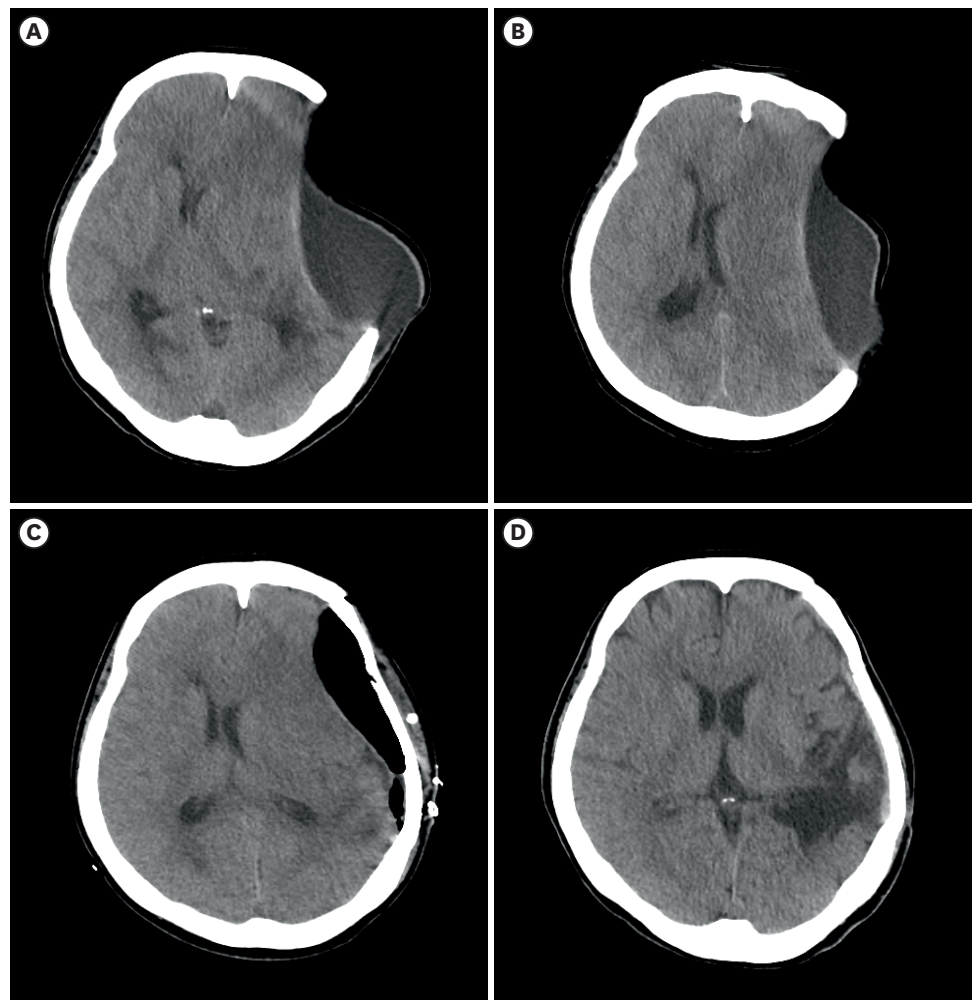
Preoperative and postoperative brain image following cranioplasty. (A) A brain CT from the second day of the shunt shows a sunken extradural cyst, ventricle, and midline shifting to opposite side. (B) A brain CT from the 6th day of the shunt shows a slightly increased ventricle, but the midline shifting is still visible. (C) The midline shifting is more improved after cranioplasty. (D) A brain CT after 3 months of cranioplasty shows completely recovered paradoxical herniation and external hydrocephalus. CT: computed tomography.
